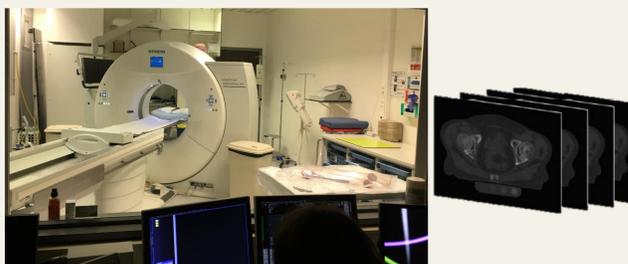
Performing CT-Scans
